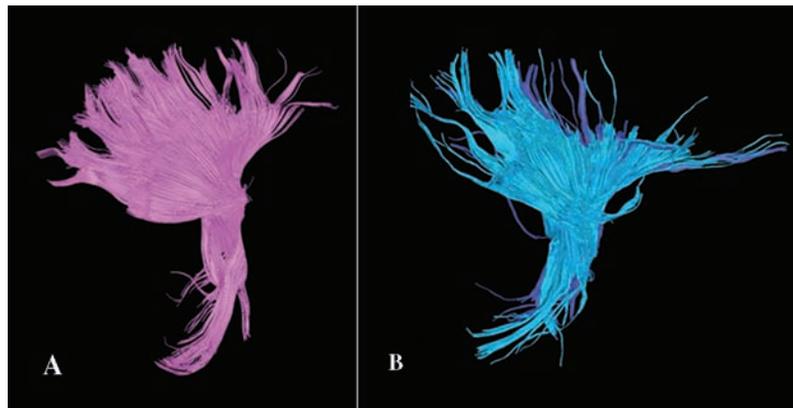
MRI tractography in sagittal view showing corona radiata and the corticospinal tract in (A) a healthy control subject and (B) ALS subject with a remarkable qualitative decrement in width and thickness in the corticospinal tract at baseline.
